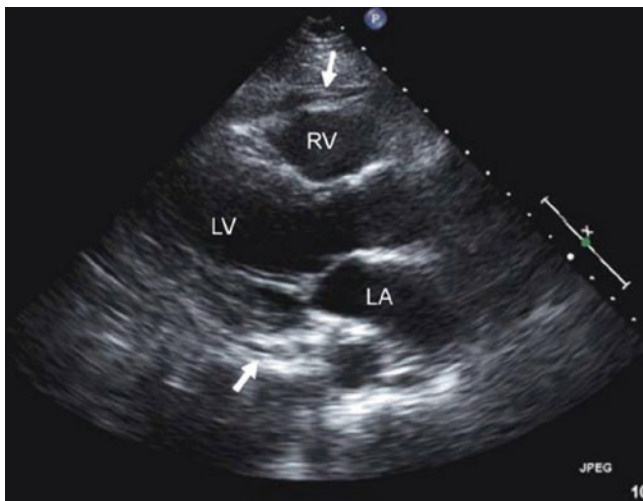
Case Study 1. Two-dimensional echocardiogram, parasternal long-axis view, demonstrating a small pericardial effusion (black arrows). LA left atrium, LV left ventricle, RV right ventricle
